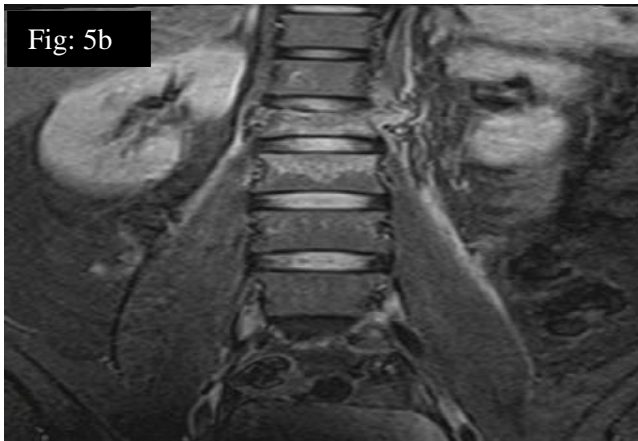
MRI Lumbar spine showing L1 compression fracture
